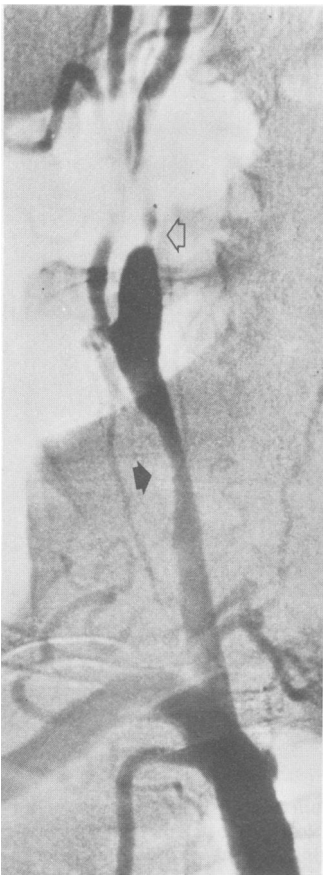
Radiograph showing short, severely narrowed segment of the right internal carotid artery 2 cm above bifurcation (white arrow) and a large area of moderate narrowing of the right common carotid artery (black arrow). Minimal irregularity of the proximal portion of the right subclavian artery is also seen.
